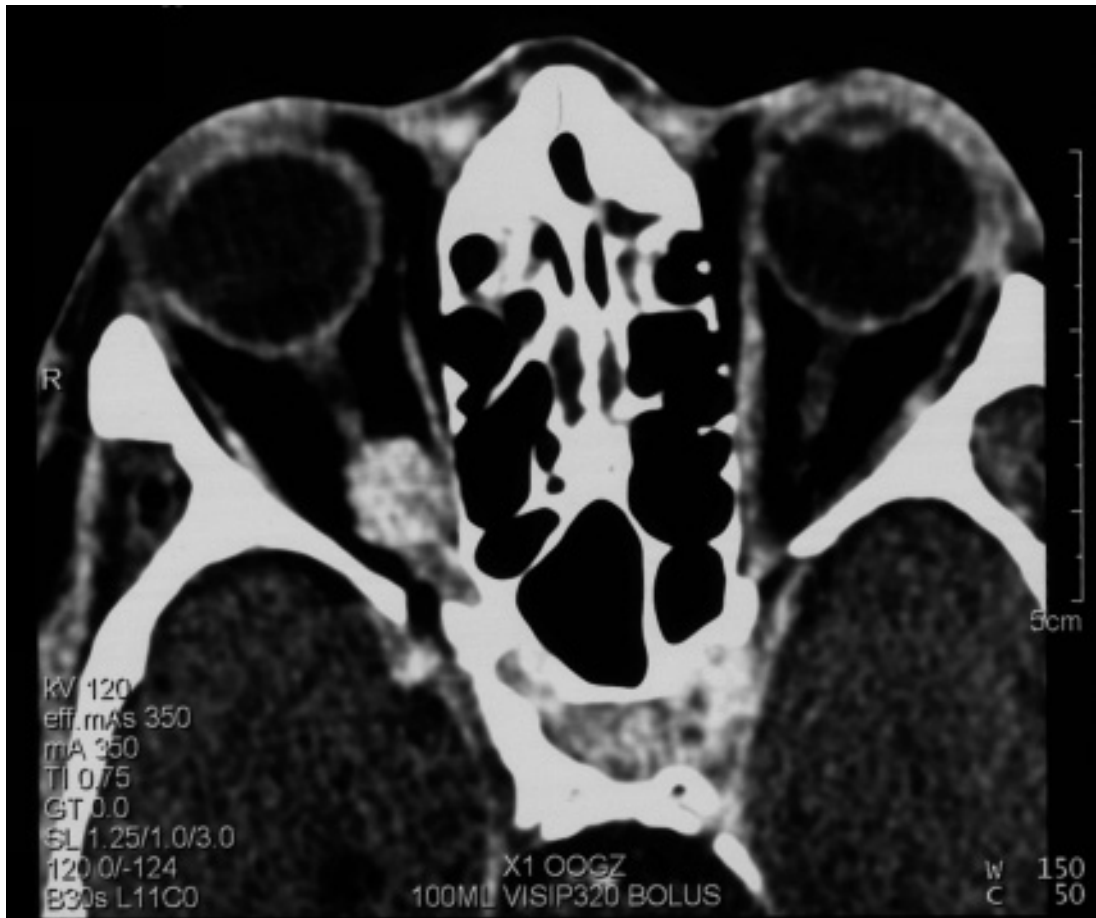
Axial orbital CT scan of September 2002 showing the ONSM, localized in the orbital apex, around and medially of the optic nerve. Note the typical tram-track sign. There is no intracranial extension of the tumour nor bone involvement.
